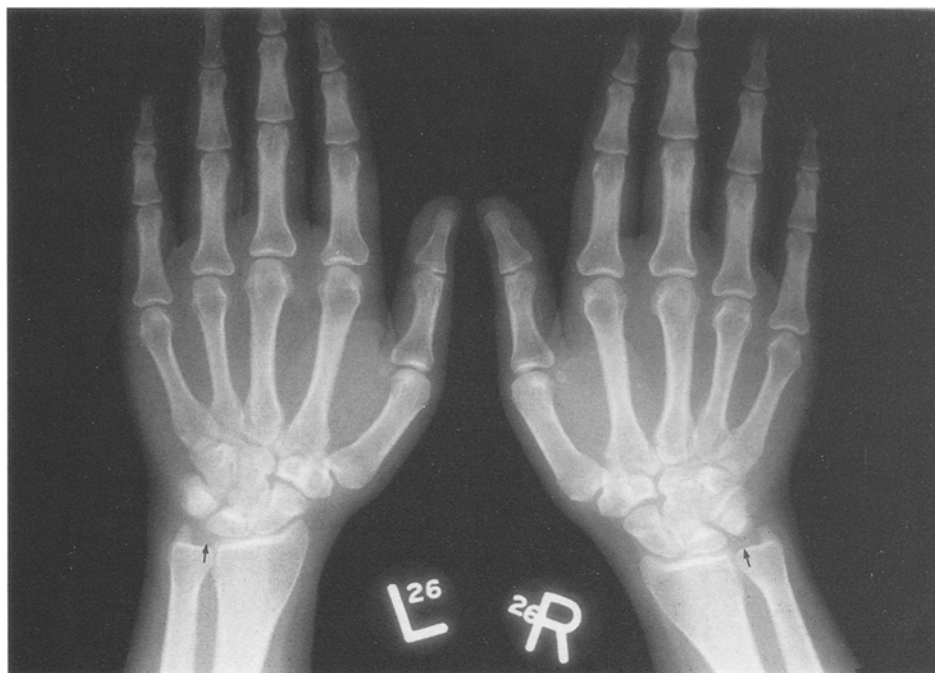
Radiographs of both hands showing chondrocalcinosis in both radiocarpal joints.
